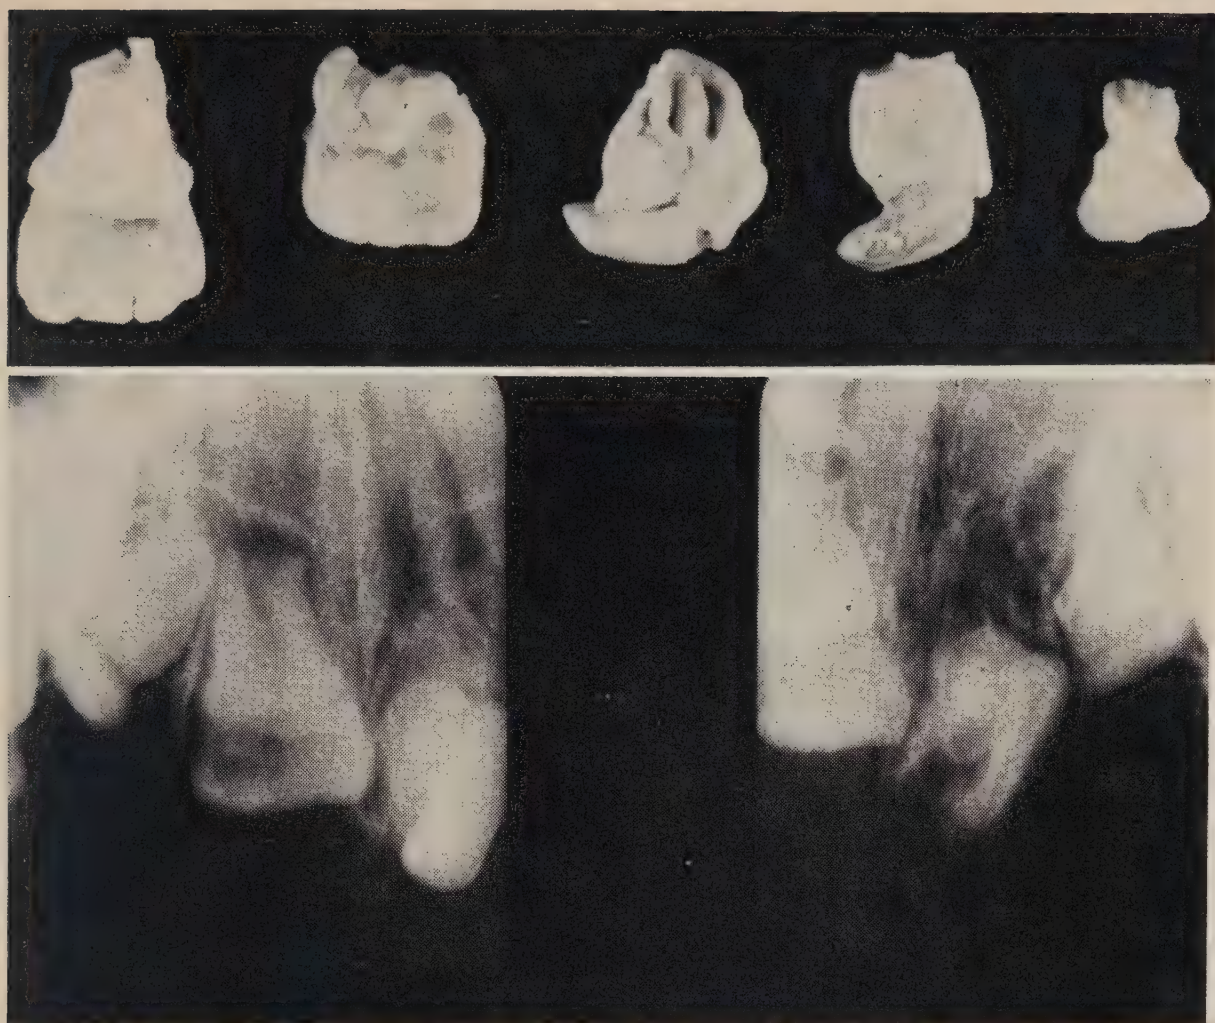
Above: dilacerated upper permanent incisors from a child who was thrown from an automobile at 14 months of age. The upper deciduous incisors were driven apically and had to be extracted when they erupted again. The four permanent incisors and a cuspid were subsequently enucleated. Below: radiographs of the deformed permanent teeth.
